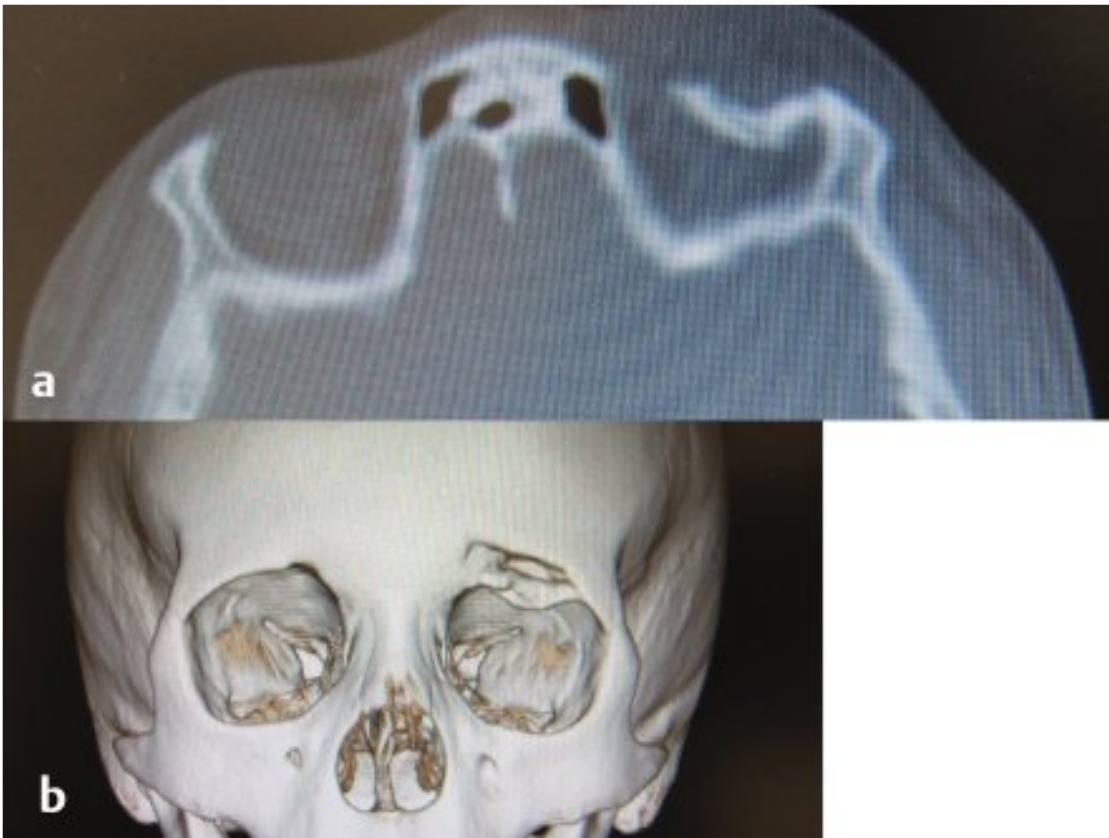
(a) Axial and (b) 3D reconstruction CT scans of a patient with an orbital roof fracture.
